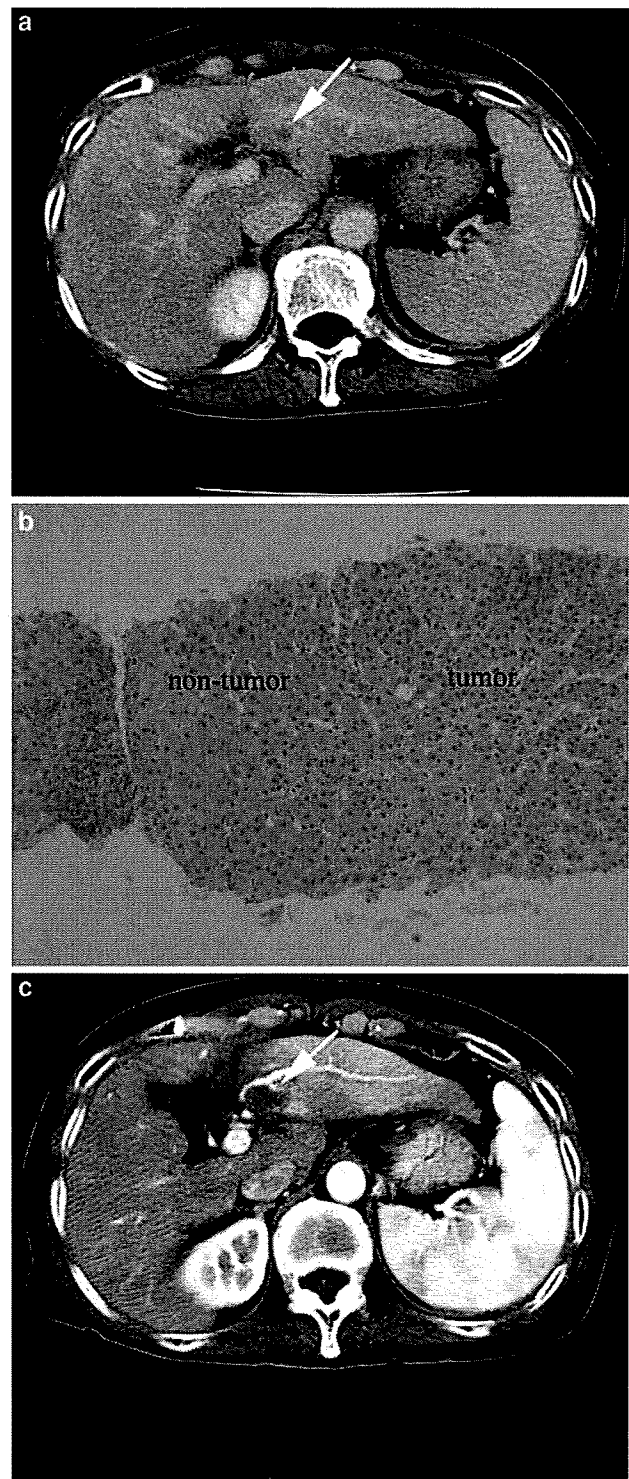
Before PEI: (a) contrast-enhanced CT revealed washout in the late phase (arrow); (b) well-differentiated HCC was observed. After PEI: (c) contrast-enhanced CT revealed an LDA (arrow)
